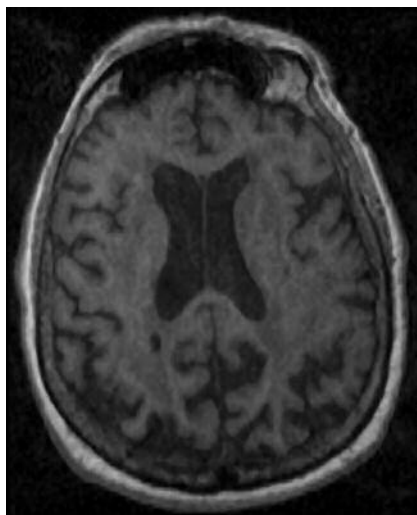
T1-weighted MRI showing a macroscopic infarction in the internal capsule adjacent to the left lateral ventricle.
